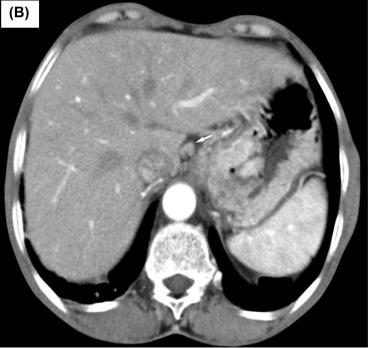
(A and B), Contrast enhanced axial chest CT images showing enlarged celiac region lymph nodes, some having hypo-dense center; the largest measuring 2.5 cm in shortest diameter.
